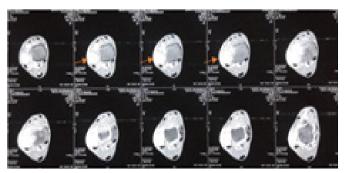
MRI Ankle Axial view.
